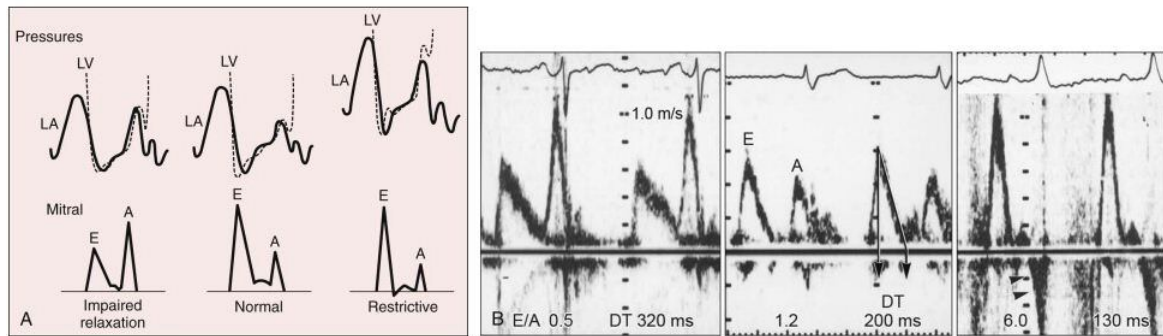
LV AND LA PRESSURE RELATIONSHIP AND CORRESPONDING MITRAL INFLOW VELOCITIES IN THREE DIFFERENT DIASTOLIC FILLING PATTERNS: IMPAIRED RELAXATION, NORMAL, AND RESTRICTIVE AND ACTUAL DOPPLER RECORDINGS ^[94]
